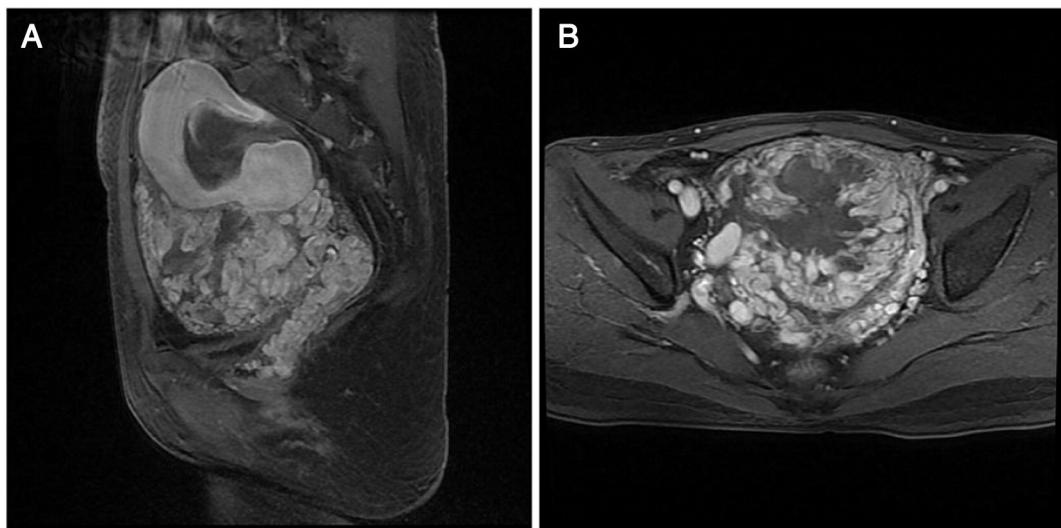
Pelvic MRI scan showing uterine cavity expansion. (A) Scan showing diffuse vascular flow void in myometrium and (B) bilateral parametrium with a significant enhancement.
